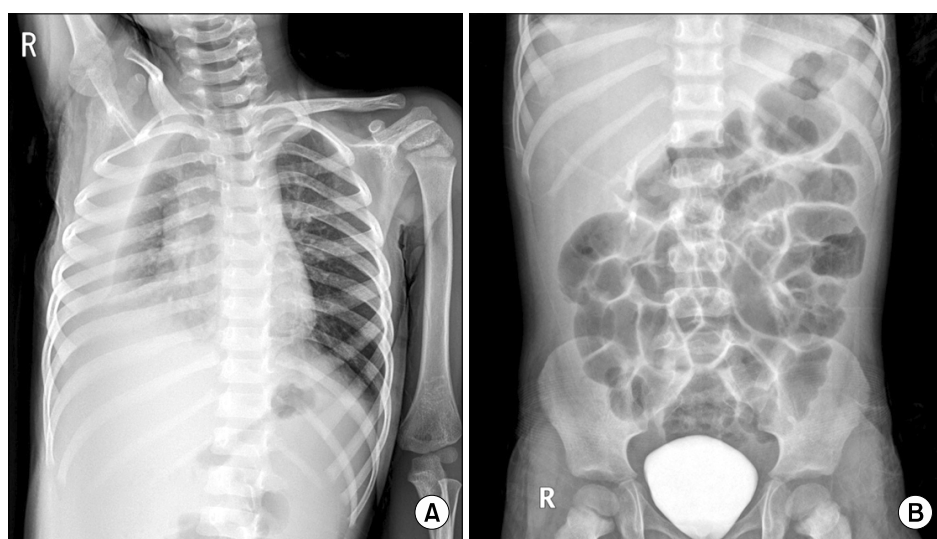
Simple radiologic findings in a previously healthy boy with hemophagocytic lymphohistiocytosis due to adenovirus infection. (A) Right decubitus chest x-ray showing a massive pleural effusion. (B) Supine abdomen x-ray showing severe gaseous dilatation and some ascites.
